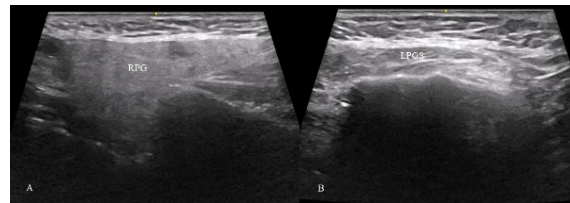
Ultrasonographic findings: The right parotid gland is visualized with preserved echotexture (A), whereas no glandular tissue is identified within the left parotid fossa (B). RPG, right parotid gland; LPGS, left parotid gland space.
